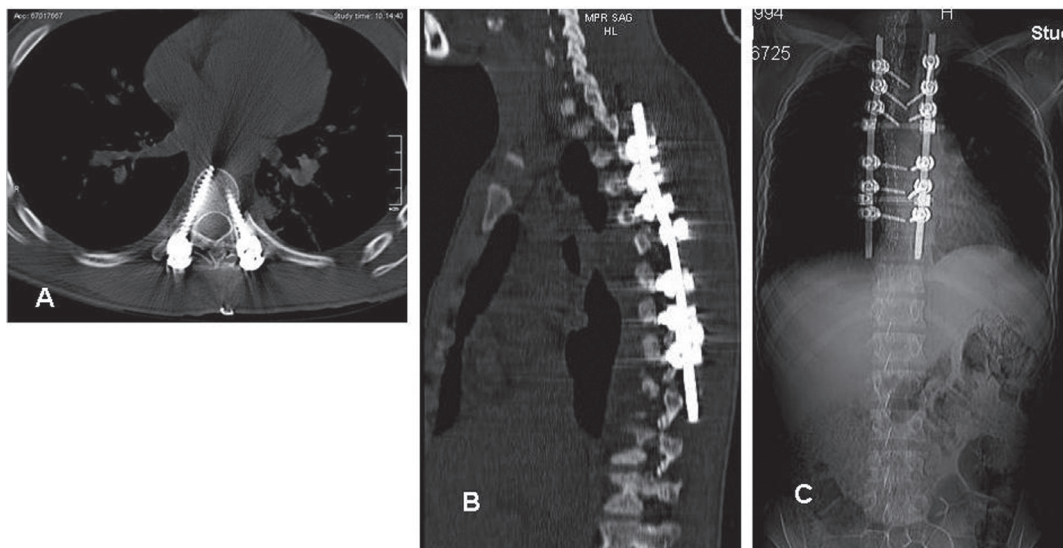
A: Postoperative axial and B: sagittal computed tomography (CT) shows proper alignment of the spinal column after pedicle screw fixation. C: Spinal axis is seen to be aligned on post-op radiograph.
